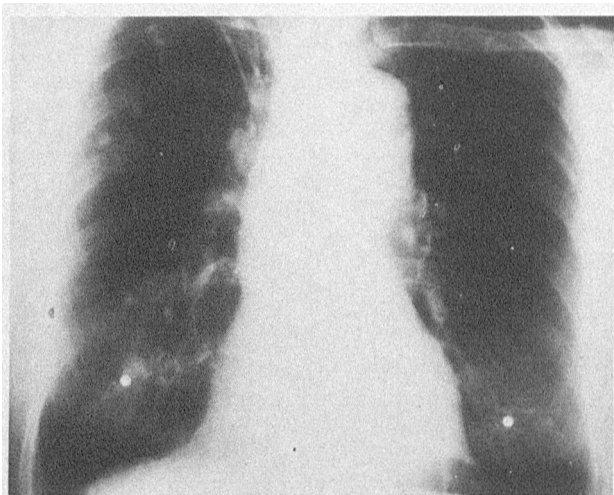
Chest Radiograph with Nipple Marker Projecting at Periphery of Lesion.
